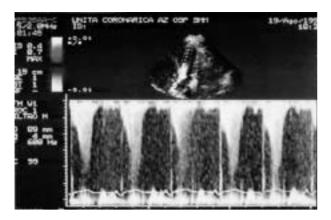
Case 1. Echocardiography. Continuous wave Doppler discloses the presence of high flow acceleration (3 m/s) due to a dynamic stenosis (scimitar shape) followed by a mid-systolic flow due to mitral regurgitation starting after the dynamic gradient had peaked.
